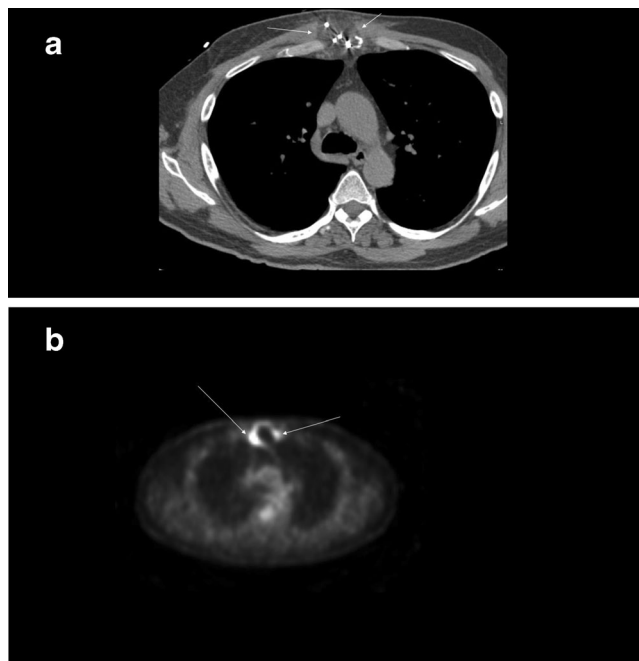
Images from a patient with symptomatic recurrence at 3 months. a Single axial CT taken during an ablation in a 61-year-old male with painful metastatic lung cancer involving the sternum demonstrates four cryoprobes (“D” from Fig. 1) and the associated ice ball (arrows). The patient had initial relief of his symptoms reflected as a reported VAS decrease from 10 to 2. b Single axial PET image obtained 3 months later demonstrates abnormal activity at the periphery of the ablation bed (arrows) corresponding to the patient’s recurrent symptoms, interpreted as either recurrence or initial “underablation”
